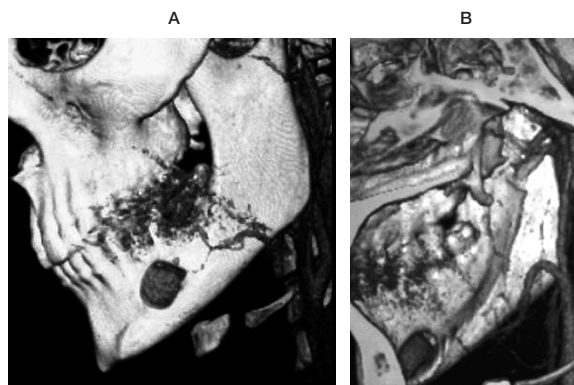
CT angiography parasagittal VRT images (A,B) allow a three-dimensional, concomitant evaluation of both vascular and osseous alterations.
